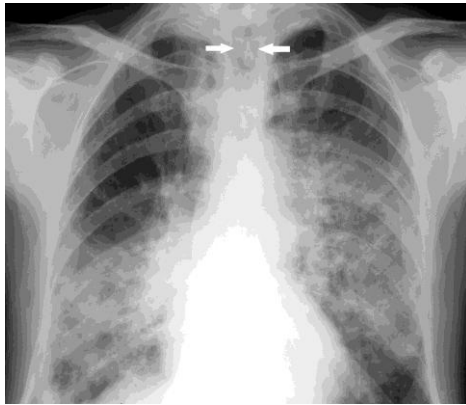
Plain chest radiograph of first case shows tracheal dilatation (arrows) and bilateral lower zone opacities which is more prominent on right (consolidation).
